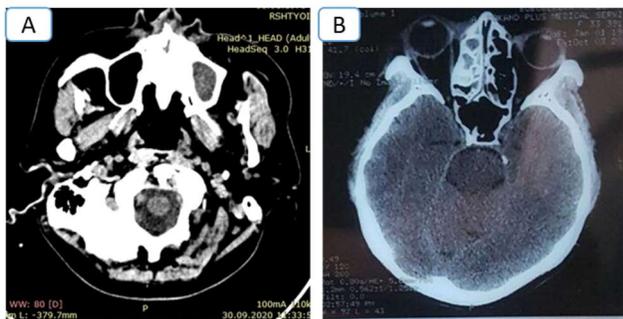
CT scans. A. On axial section, signs of left-sided hemi sinusitis are determined (the presence of contents in the cavity of the maxillary and ethmoid sinuses in density (35-45) close to pus). B. On axial section, signs of right-sided hemi sinusitis are determined, possible presence of pus in orbit with exophthalmos.
